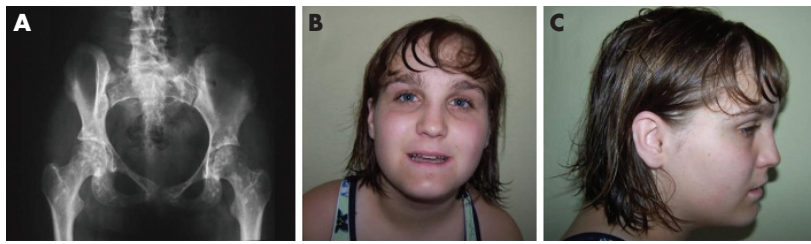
Clinical and radiographic features of the microdeletion syndrome. (A) Radiograph of the pelvis in patient 03g1858 showing multiple osteopoikilosis lesions in the proximal parts of the femurs and pubic bones. Facial phenotype of patient D0502619 with anteroposterior (B) and lateral (C) view (patients 03g1858 and #4818 refused clinical photographs). Parental/guardian informed consent was obtained for publication of this figure.
